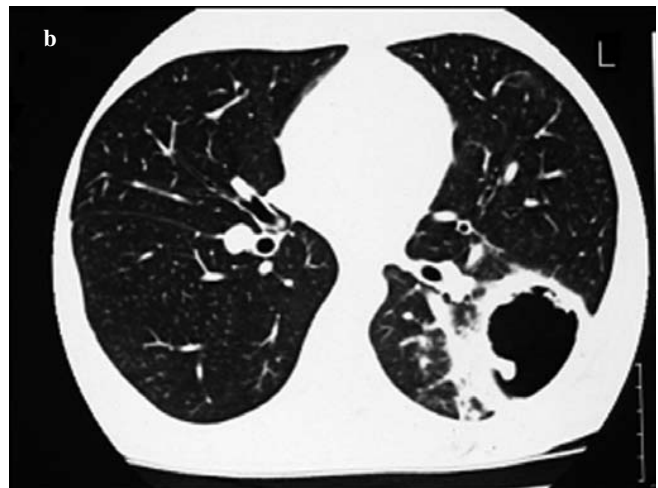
Inspiratory chest high-resolution computed tomography (HRCT) scan. a In the mediastinal window a large cavitated mass with thick irregular walls is depicted, which seems to communicate with the peripheral airways. b In the lung window, the mass is surrounded by ground-glass opacity (CT halo sign, indicating pulmonary haemorrhage).
